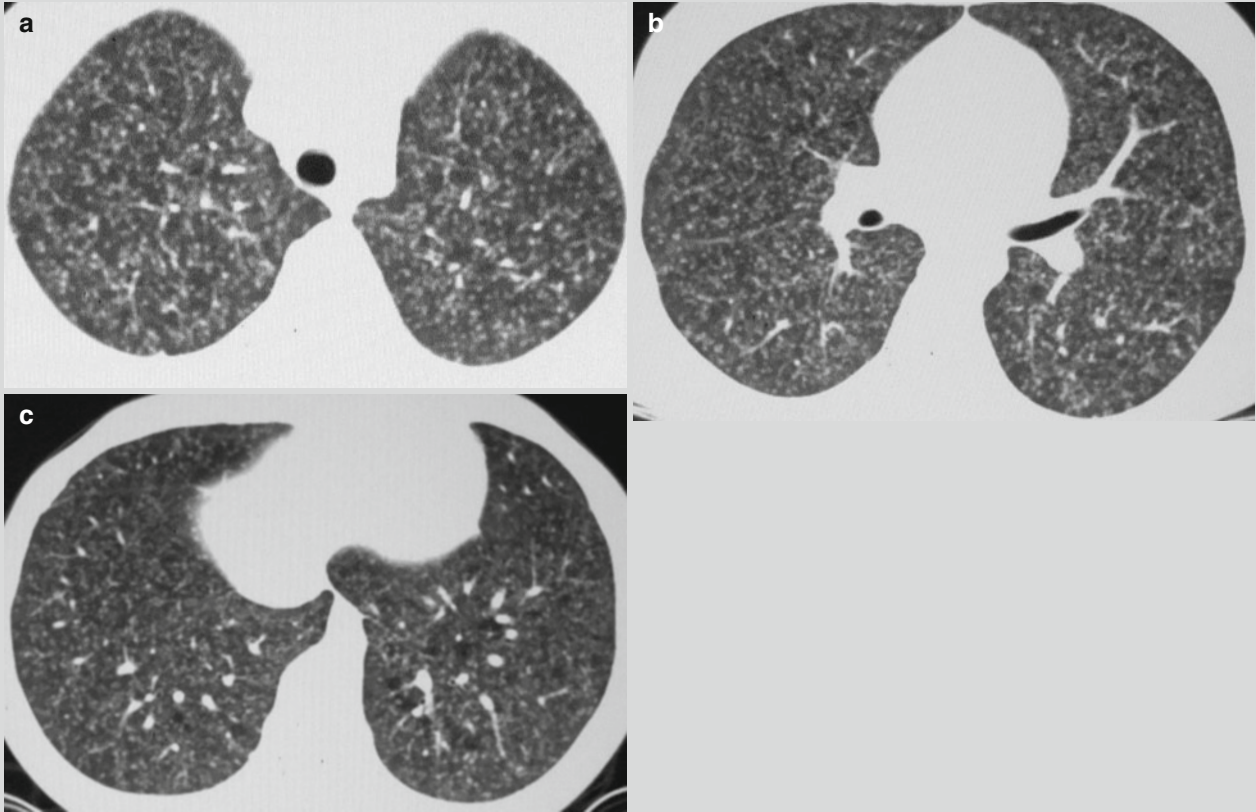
Acute hematogenous pulmonary TB. (a–c) CT scanning demonstrates diffuse miliary shadows at both lungs, with even size, even density and even distribution
